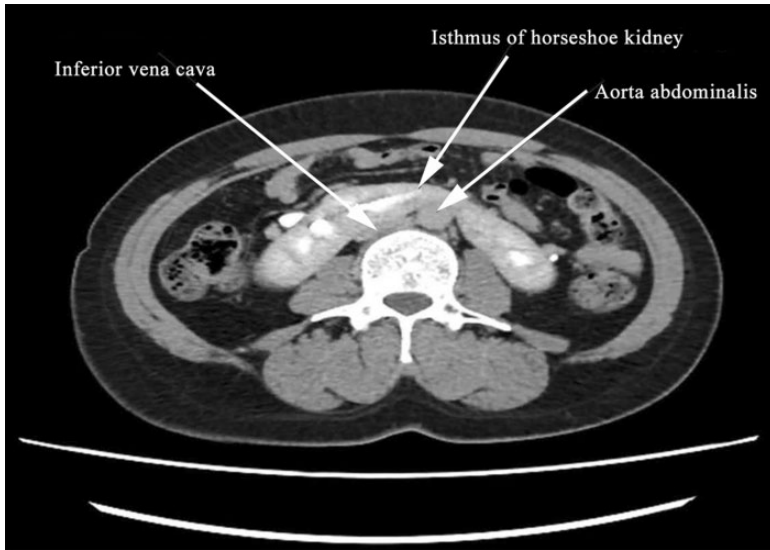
Preoperative computed tomography image of a 42-year-old woman (gravida 2, para 2) who complained of bleeding after intercourse for 1 month. The image was suggestive of a space-occupying lesion and horseshoe kidney.
